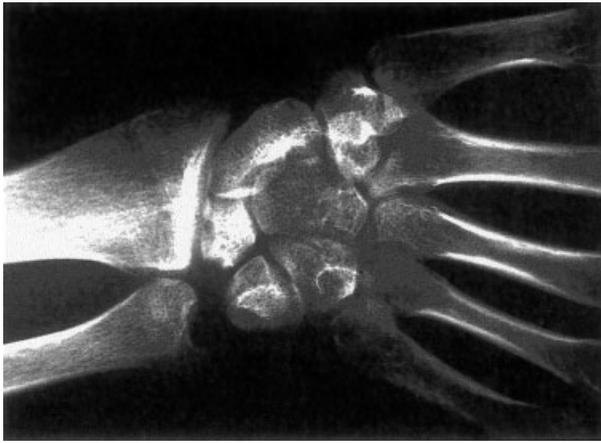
X-ray photograph showing Kienbock disease in a C6 level young tetraplegic patient.
